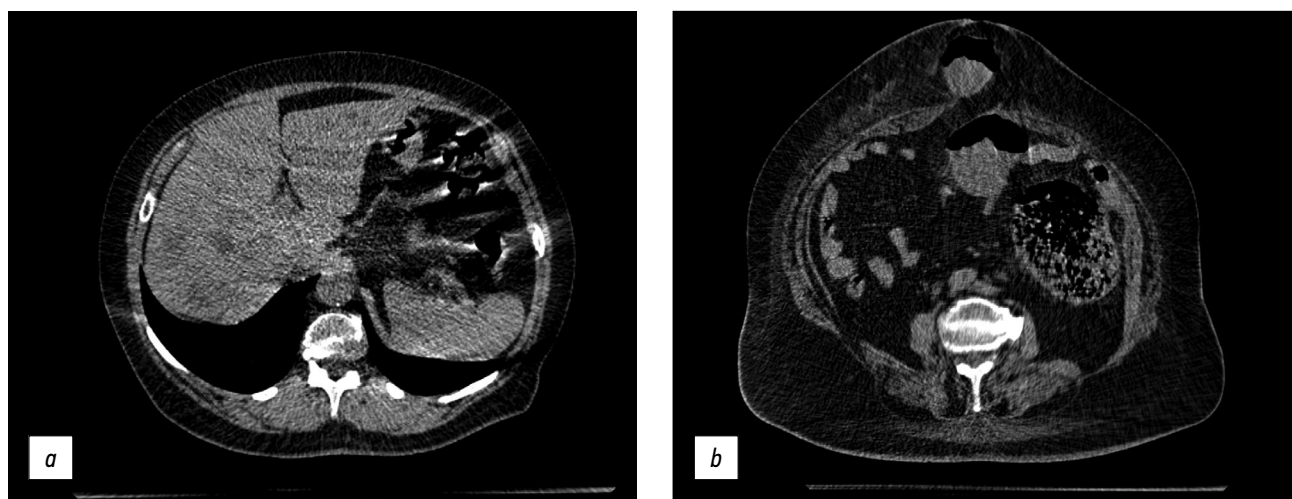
Axial computed tomographic images of the abdomen: (a) CT image of multiple hypodense lesions of both liver lobes, helical artifacts, and gas interface artifacts in the intestinal area and (b) CT image of a strangulated umbilical hernia.
